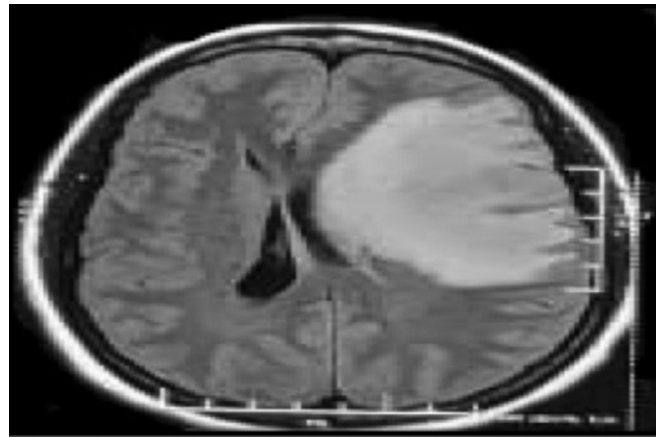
MRI brain contrast showing left frontal lobe lesion with significant perilesional edema causing mass effect
